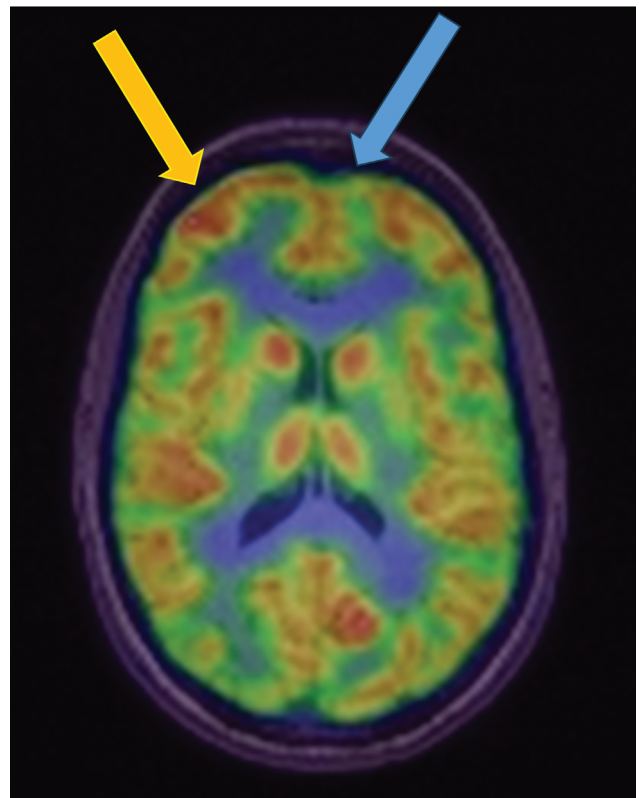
Axial attenuation corrected fused FDG PET-MR images of the brain in a 35-year-old female with history of prior concussions particularly to the front of the head, obtained for research purposes. In this case, there was decreased metabolism in the left superior frontal region (blue arrow) along with increased metabolism in the right frontal region. A common finding in patients with post-concussion syndrome is a mix of areas of increased and decreased metabolism. These findings correlate with symptoms such as poor concentration when frontal lobe metabolism is abnormal. Image courtesy of Dr. Andrew B. Newberg.
